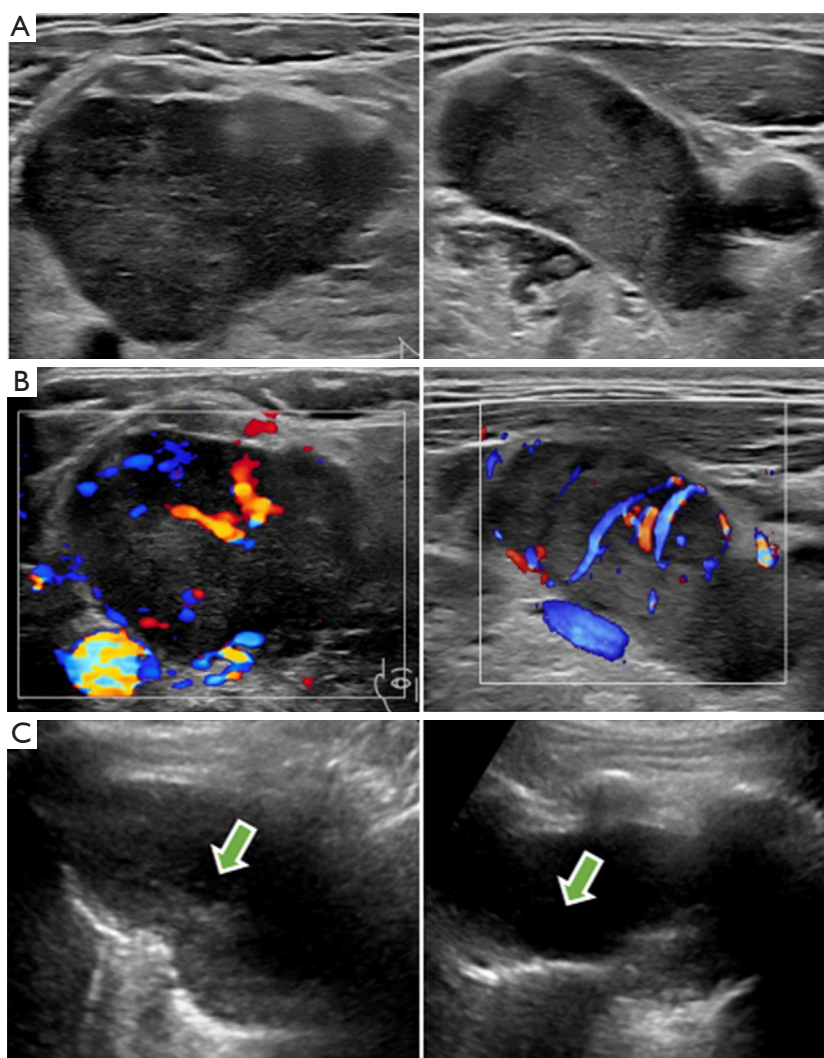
Two-dimensional ultrasound images of cervical lymph nodes and mediastinal masses. (A) Two-dimensional ultrasound images of enlarged lymph nodes in the right and left neck. (B) Color Doppler ultrasound images of enlarged lymph nodes in the right and left neck. (C) Two-dimensional ultrasound shows transverse and longitudinal views of the posterior mediastinal mass, with an echogenic area seen inside (green arrows).
